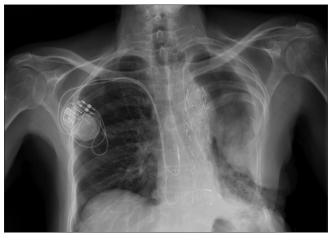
Chest X-ray posteroanterior view showing both aortic and esophageal stents *in situ*
